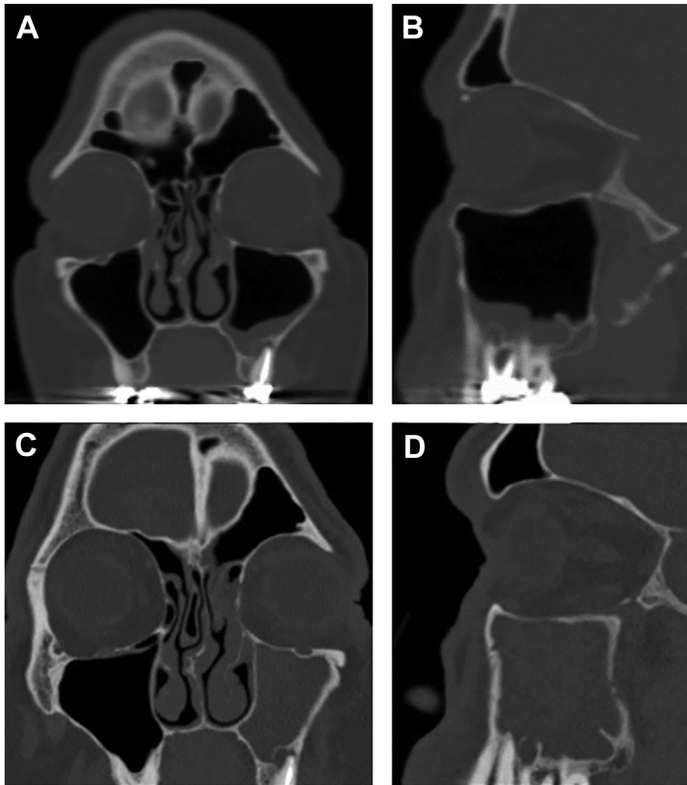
Example of a patient with left-sided ODS that developed over years following a prior RCT of the first maxillary molar. (A, B) Computed tomography (CT) scans showing left maxillary sinus mucosal thickening (reactive mucositis) after an RCT of the first maxillary molar which had apical periodontitis with a periapical radiolucency and bone erosion. (C, D) Ten years later, the patient had been developing left-sided sinusitis symptoms and CT showed complete maxillary sinus opacification with the persistent periapical radiolucency with bone erosion which gradually caused a purulent ODS over time. The patient underwent endoscopic sinus surgery (ESS) for symptomatic control, and eventually he decided to have the tooth extracted as well.
